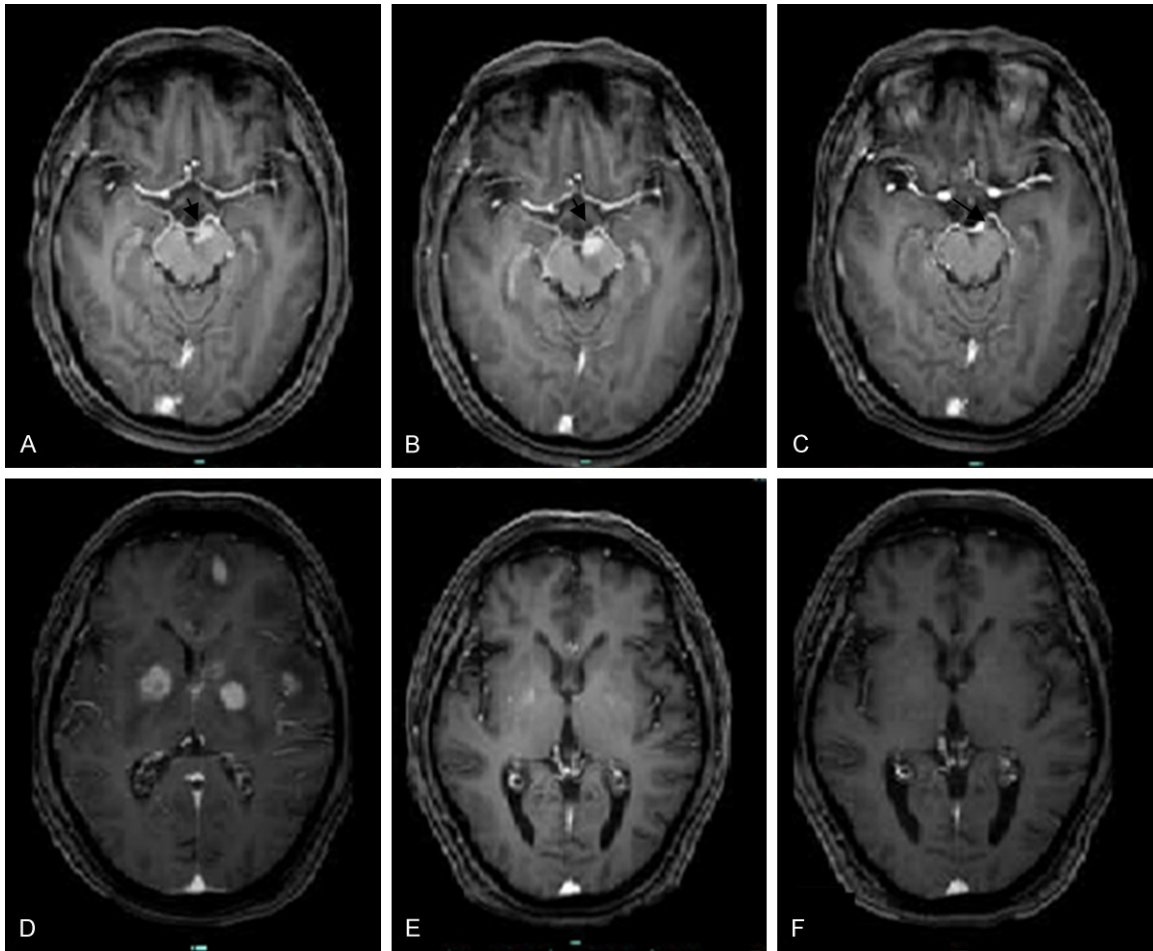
Seriated MRI analysis showing tumor progression and reduction over time in two patients: A: Exam performed on 4/11/2013 showing a large mass on the left lateral ventricle horn(case 1); B: MRI showed the tumor lesion was progression after two courses of MTX monotherapy 10/12/13 (case1); C: No abnormal change seen from the enhanced brain MRI after one course of MT regimen therapy performed on 2/2/14 (case1); D: MRI performed on 4/10/2014 showing multiple metastatic brain tumors (case 2); E: Exam performed on 10/11/2014, 1 week after the MT chemotherapy was administered , showing a significant tumor reduction (case 2); F: From the enhanced MRI performed on 7/1/2015, the original lesions was hardly seen after 3 courses of MT chemotherapy (case 2).
